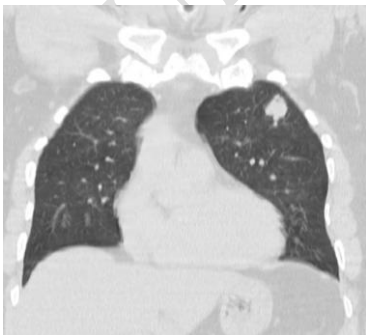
Chest computed tomography scan showing the lung nodule
